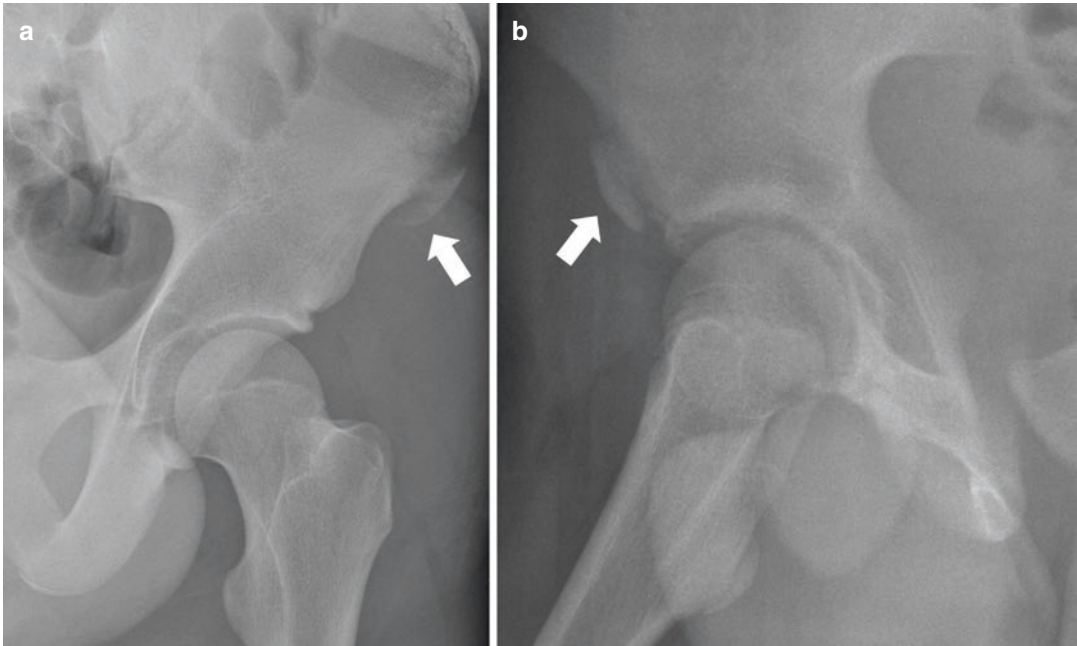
(a, b) Iliac spine avulsion injuries. Oblique hip radiographs in adolescent males after (a) sprinting and (b) football injuries, depicting apophyseal avulsion fractures (arrows) of the (a) ASIS and (b) AIIS. *AIIS* anterior inferior iliac spine, *ASIS* anterior superior iliac spine
